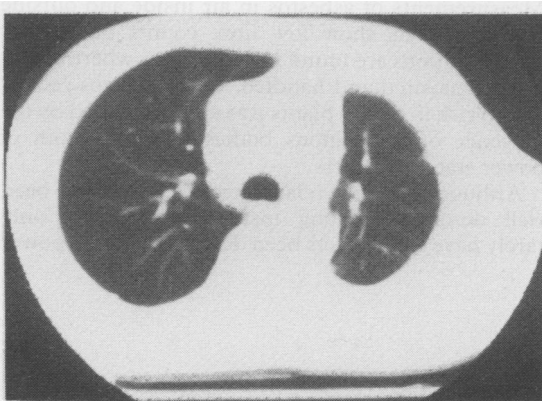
Computed tomography of chest showing encasement of left lung with thick pleural mass accompanied by pleural effusion. Calcified pleural plaque is seen on right posterior surface of pleura.
